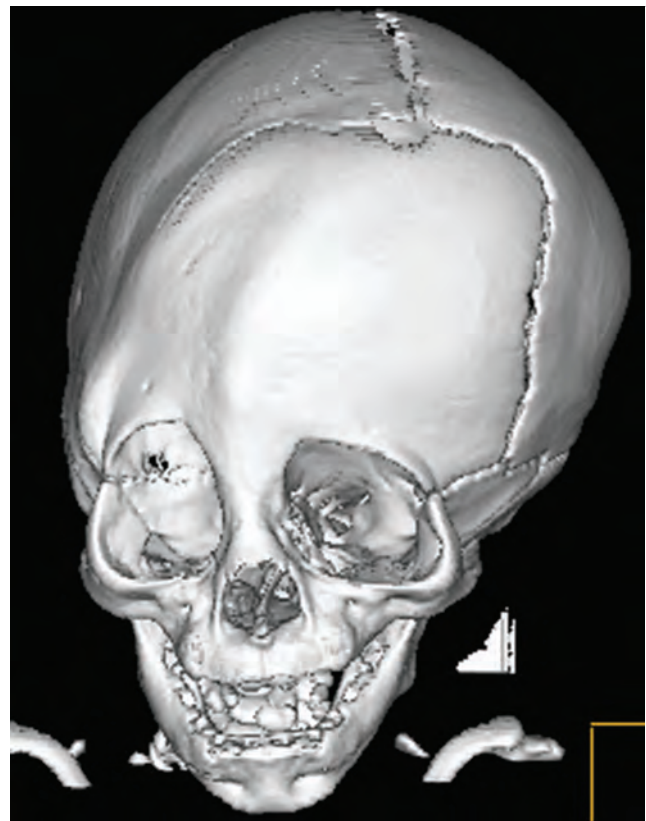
CT image of combined right unilateral coronal and metopic synostosis.
